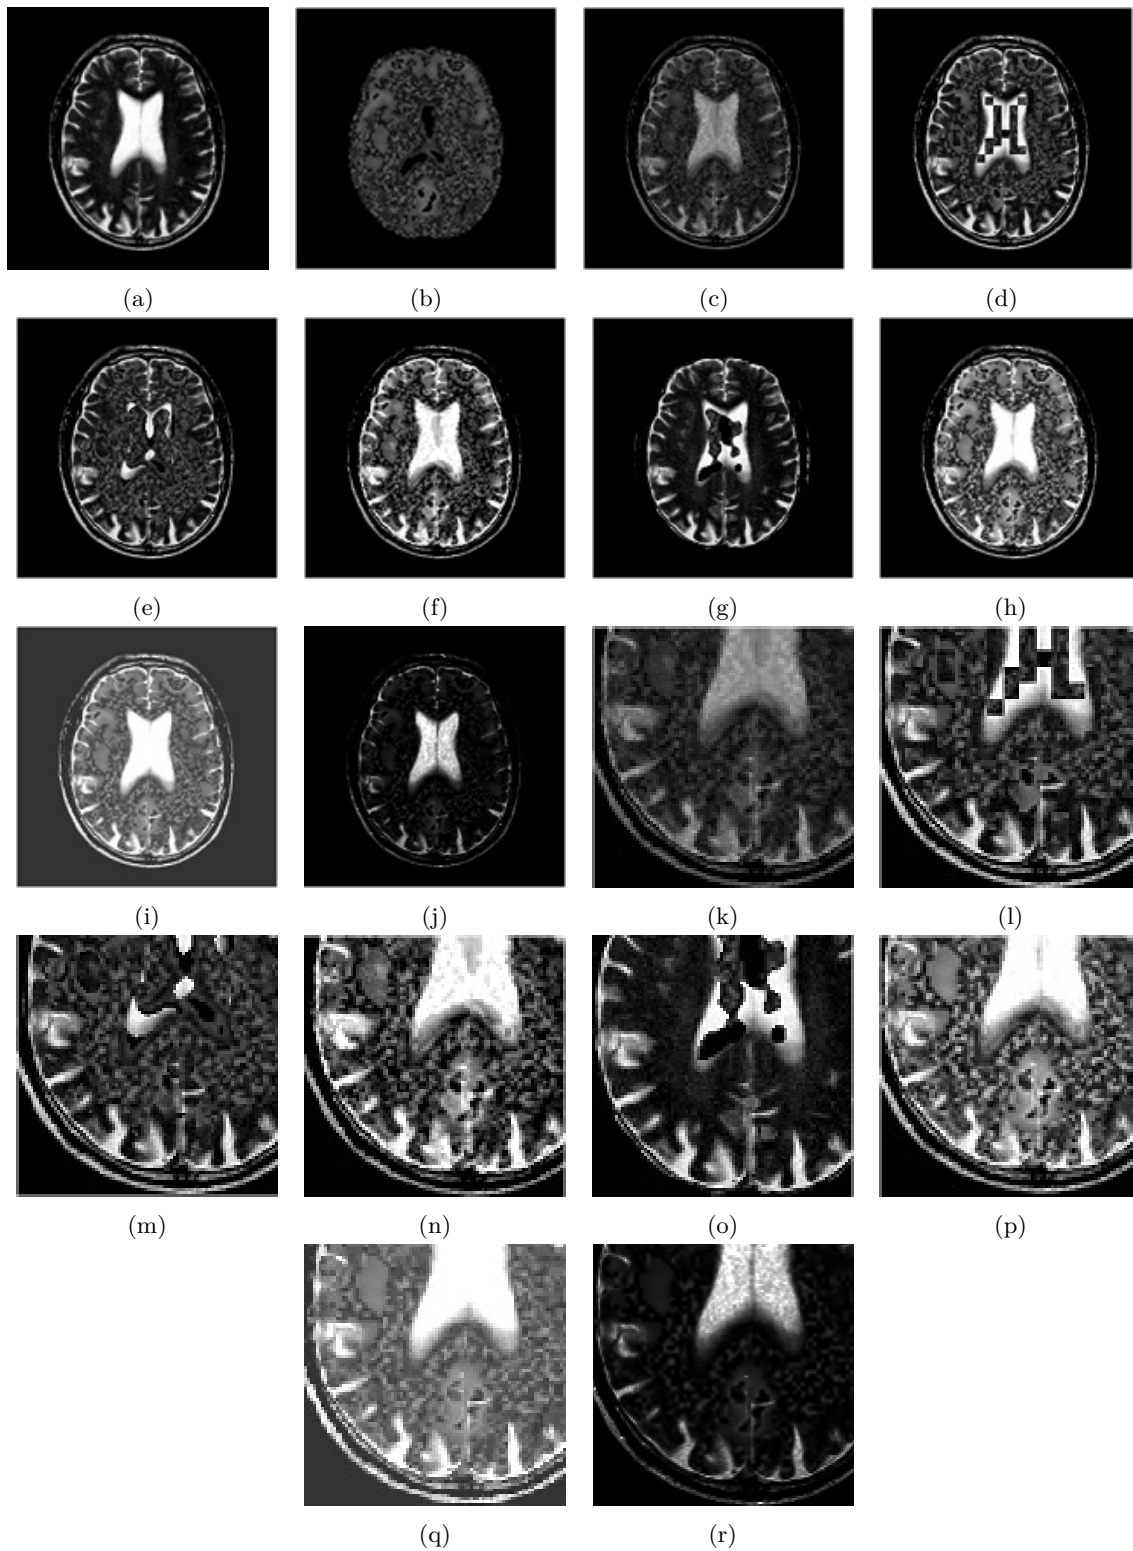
Fusion results for MRI and PET images. (A) MRI image (B) PET image (C) Fused image by simple average (D) Fused image by DCT (E) Fused image by RWT (F) Fused image by Intuitionistic fuzzy set (G) Fused image by Fuzzy transform (H) Fused image by proposed method (I) Fused image by Interval-valued intuitionistic fuzzy set (J) Fused image using Yue Entropy [38] (K), (L), (M), (N), (O), (P), (Q), (R) are the magnified results of (C), (D), (E), (F), (G), (H), (I) and (J) respectively.
